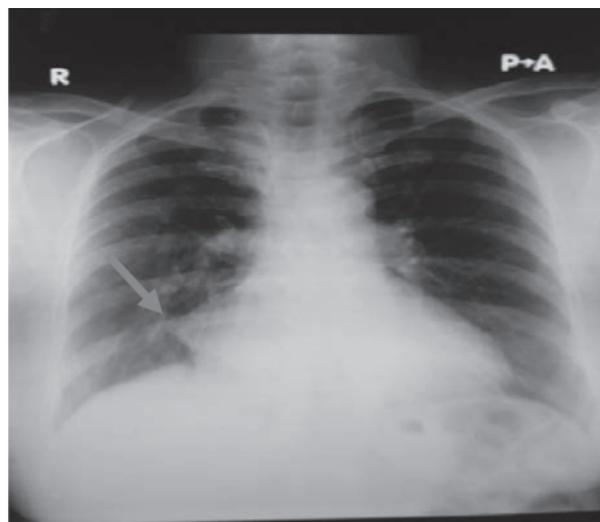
Chest Xray showing a well defined homogenous opacity near the right para cardiac border silhouetting the lower right cardiac border.
